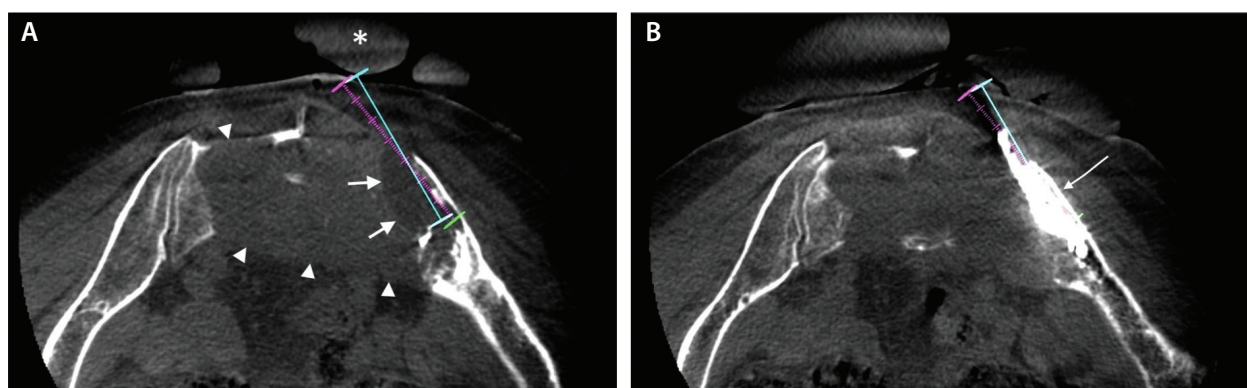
Axial cone-beam CT image of the pelvis of a 57-year-old woman with metastatic lung cancer largely replacing the sacrum (arrow heads) (A). An ice ball has been generated (arrows) using an IceRod cryoprobe (Boston Scientific Corporation) targeted at the bone-tumor interface. The medial lesion has not been treated due to localization of the patient's pain laterally and risk to the sacral nerves. A sterile glove containing warm sterile saline at the skin's surface reduces the risk of thermal injury (\*). An axial cone-beam CT image of the same patient after cementoplasty (arrow) to repair the weight-bearing portion of the sacroiliac joint (B).
